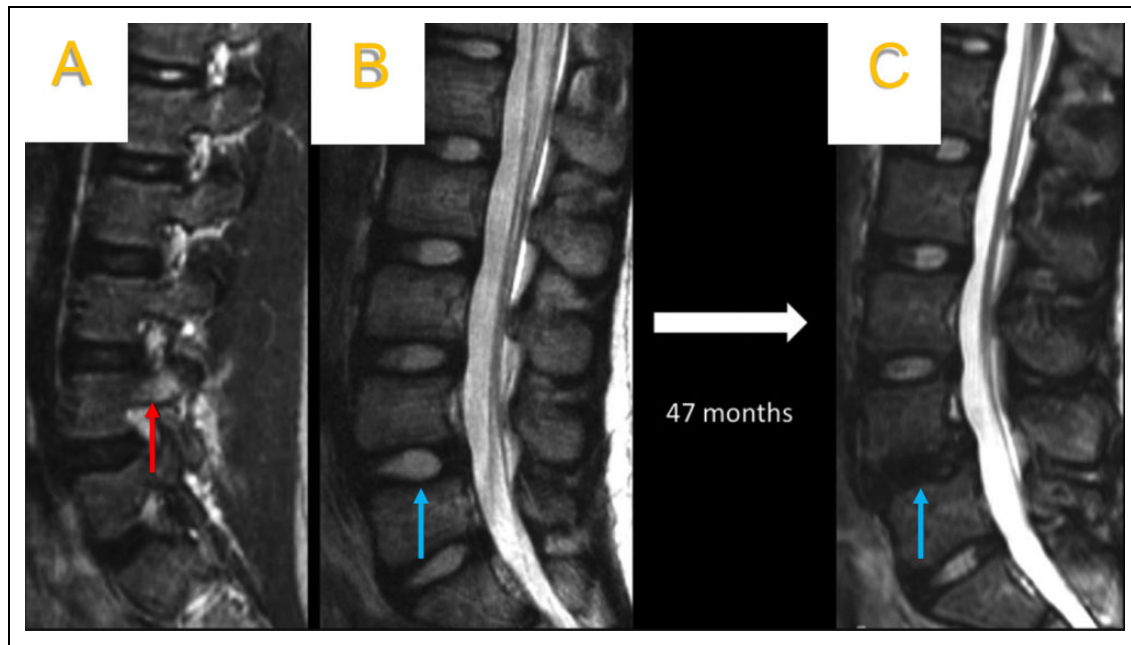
(A) T2 weighted mid-sagittal cut on magnetic resonance imaging (MRI) of a 12-year-old female patient showing edema in the L4 right pedicle (red arrow). MRI from initial presentation (B) and 47-month follow up (C) shows the progression of L4-L5 disc degeneration (blue arrows). Other discs in the lumbar spine, including the L5-S1 disc that normally experiences the greatest axial load, are spared from degeneration.⁷ Image courtesy Sharma et al 2017.
